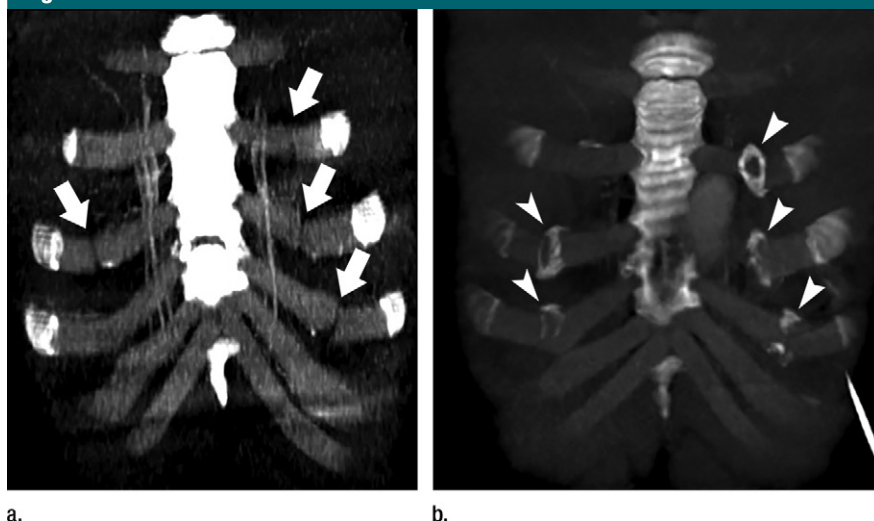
Coronal oblique maximum intensity projection (10 mm) images in a 27-year-old man with mental illness who attempted a backflip from fourth-floor window. Fourteen weeks after initial trauma, patient jumped from height of 20 m and whole-body CT was repeated. (a) Multiple bilateral CC fractures (arrows) in ribs 3–5 on left and rib 4 on right are shown. (b) Fracture of right fifth rib cartilage is revealed by posttraumatic calcifications at fracture sites (arrowheads) because it is not visible in primary CT study (a).
